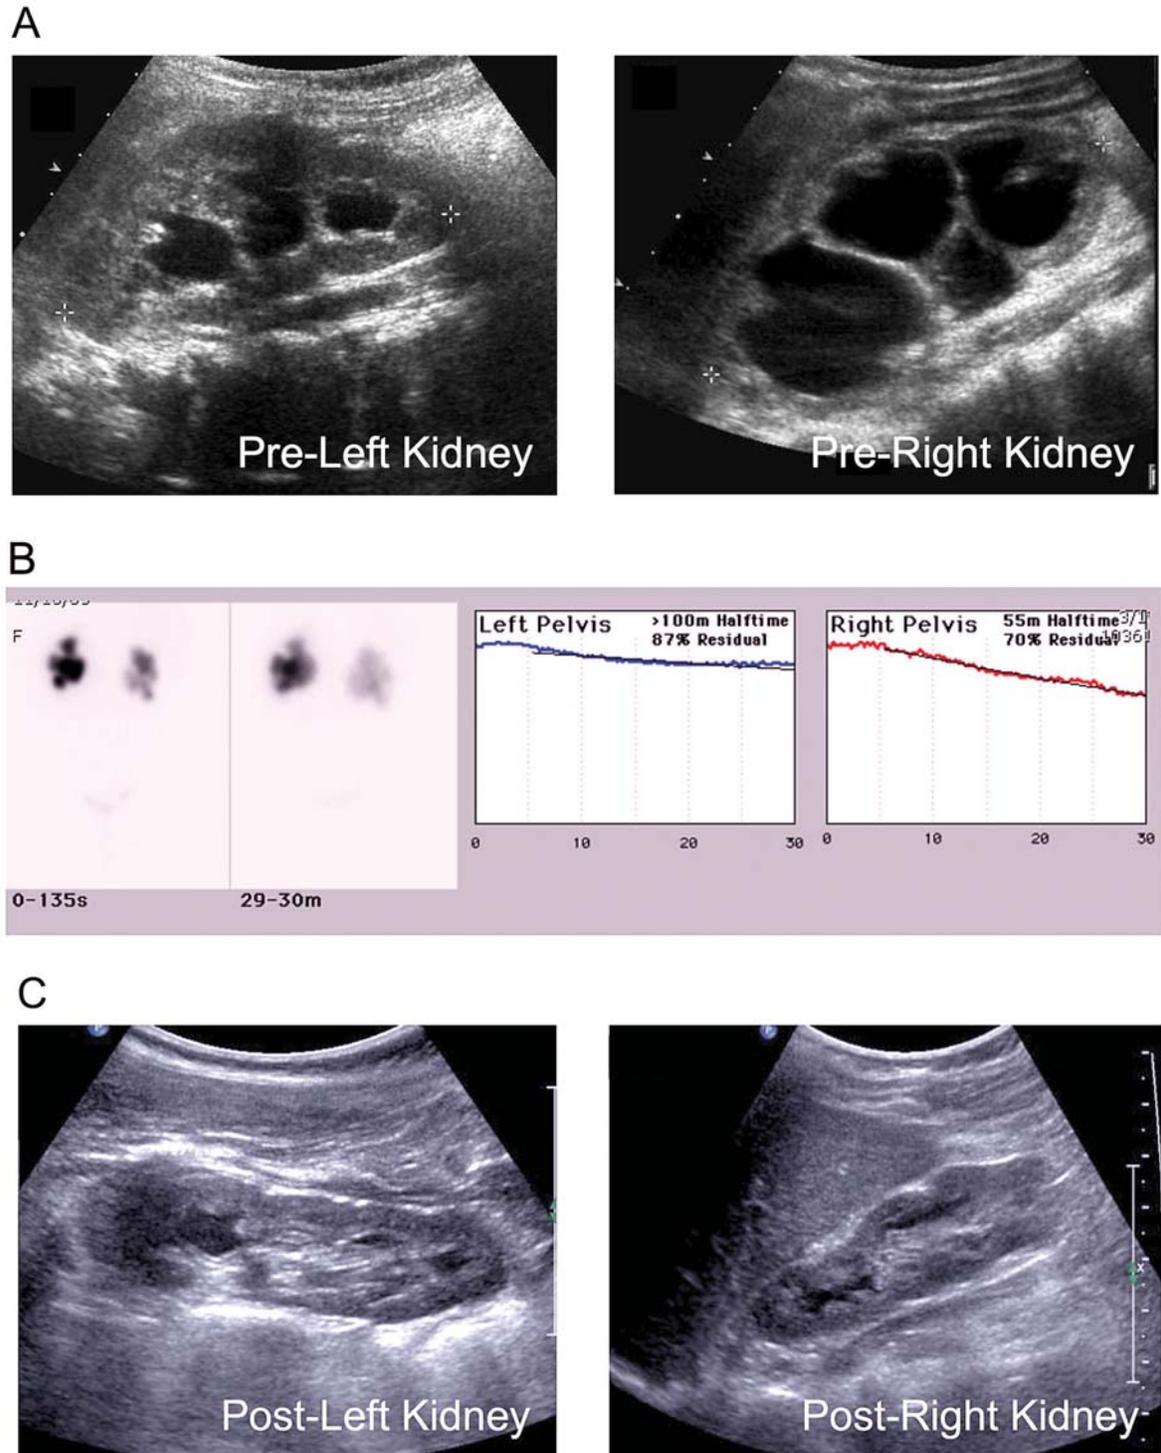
Ultrasound findings. A) Preoperative ultrasound reveals moderate hydronephrosis of the left and severe hydronephrosis of the right kidney. B) Preoperative diuretic MAG-3 renogram demonstrating significant residual of the radionuclide in both kidneys after furosemide administration. C) Postoperative ultrasound demonstrates no hydronephrosis in the right kidney and minimal pelvicaliectasis in the left kidney 2 months after surgery.
